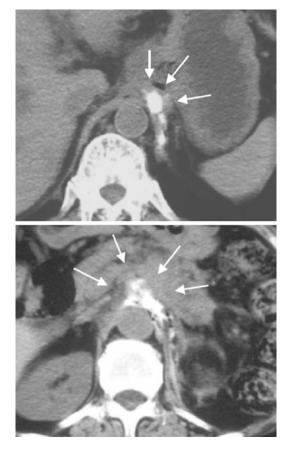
Distribution of fluids upon injection of absolute alcohol mixed with fluoroscopic contrast agents around the base of the celiac trunk and the celiac plexus ganglia after EUS-FNI: the CT scans show the typical distribution of fluids after a unilateral injection and, b after bilateral injection
